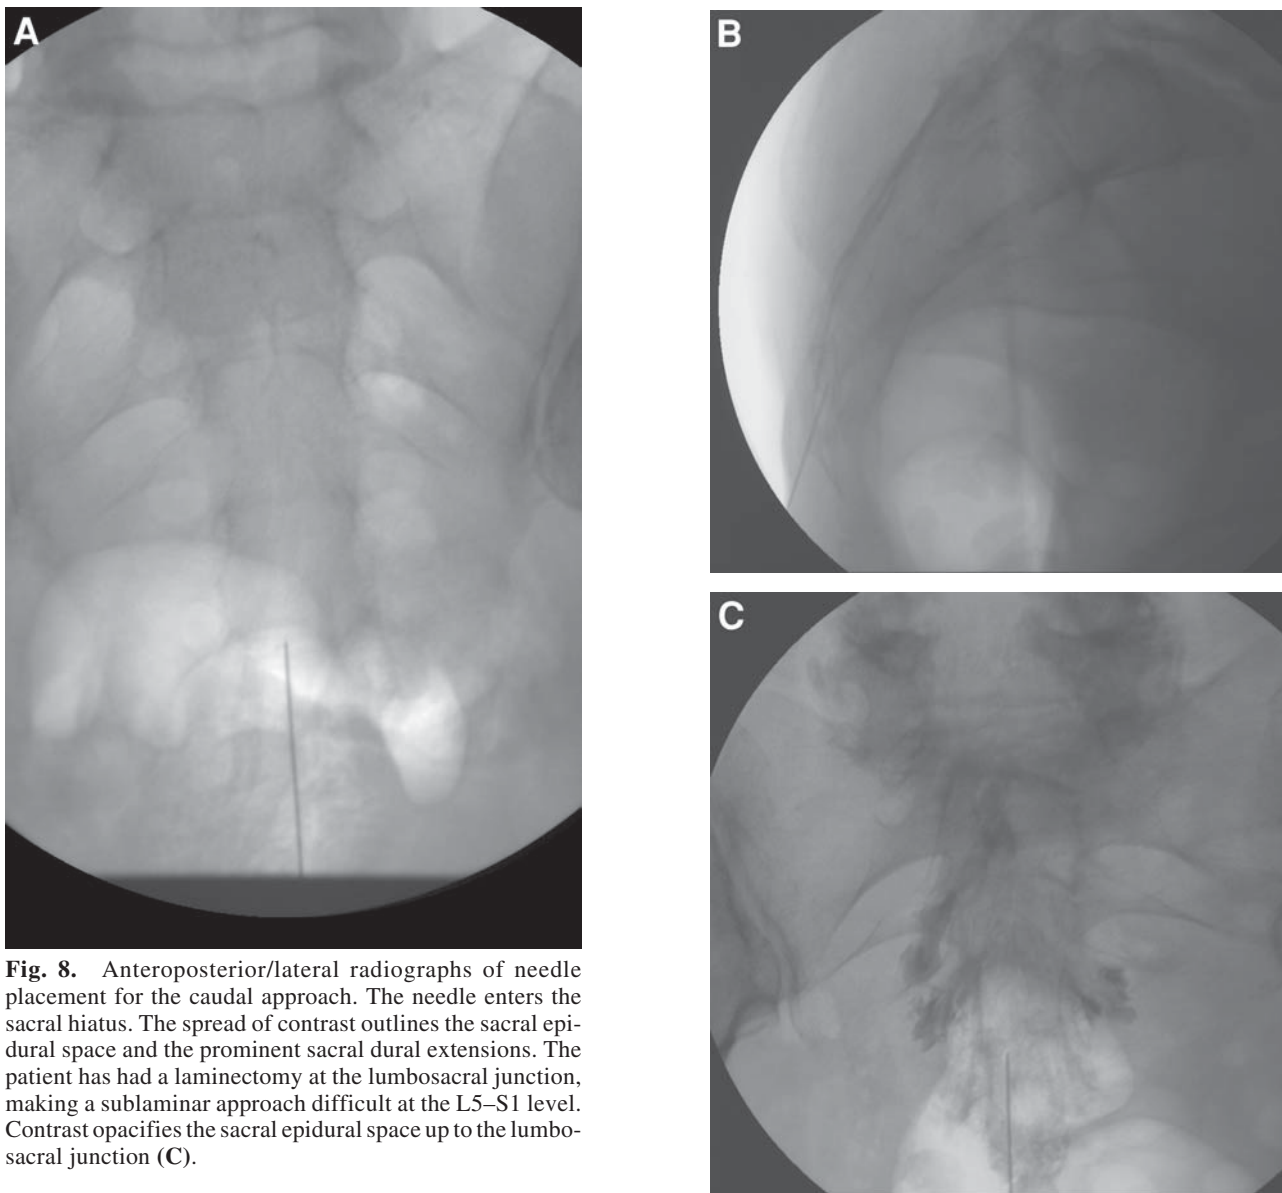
Anteroposterior/lateral radiographs of needle placement for the caudal approach. The needle enters the sacral hiatus. The spread of contrast outlines the sacral epidural space and the prominent sacral dural extensions. The patient has had a laminectomy at the lumbosacral junction, making a sublaminar approach difficult at the L5–S1 level. Contrast opacifies the sacral epidural space up to the lumbosacral junction (C).
